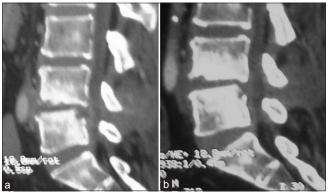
(a) Discitis with anterior abscess and small disc space abscesses; (b) 1 year followup CT sagittal reconstruction showing resolution
